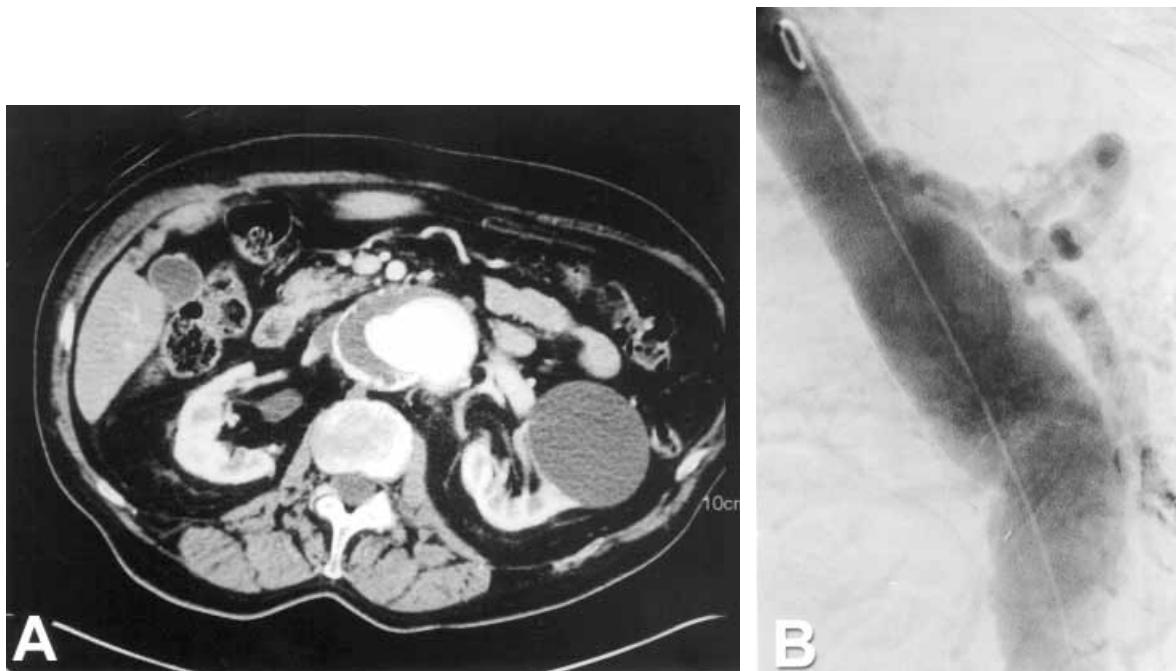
A, CT scan of patient 3 demonstrating thrombus within patch aneurysm. B, Lateral view of angiogram of same area.
